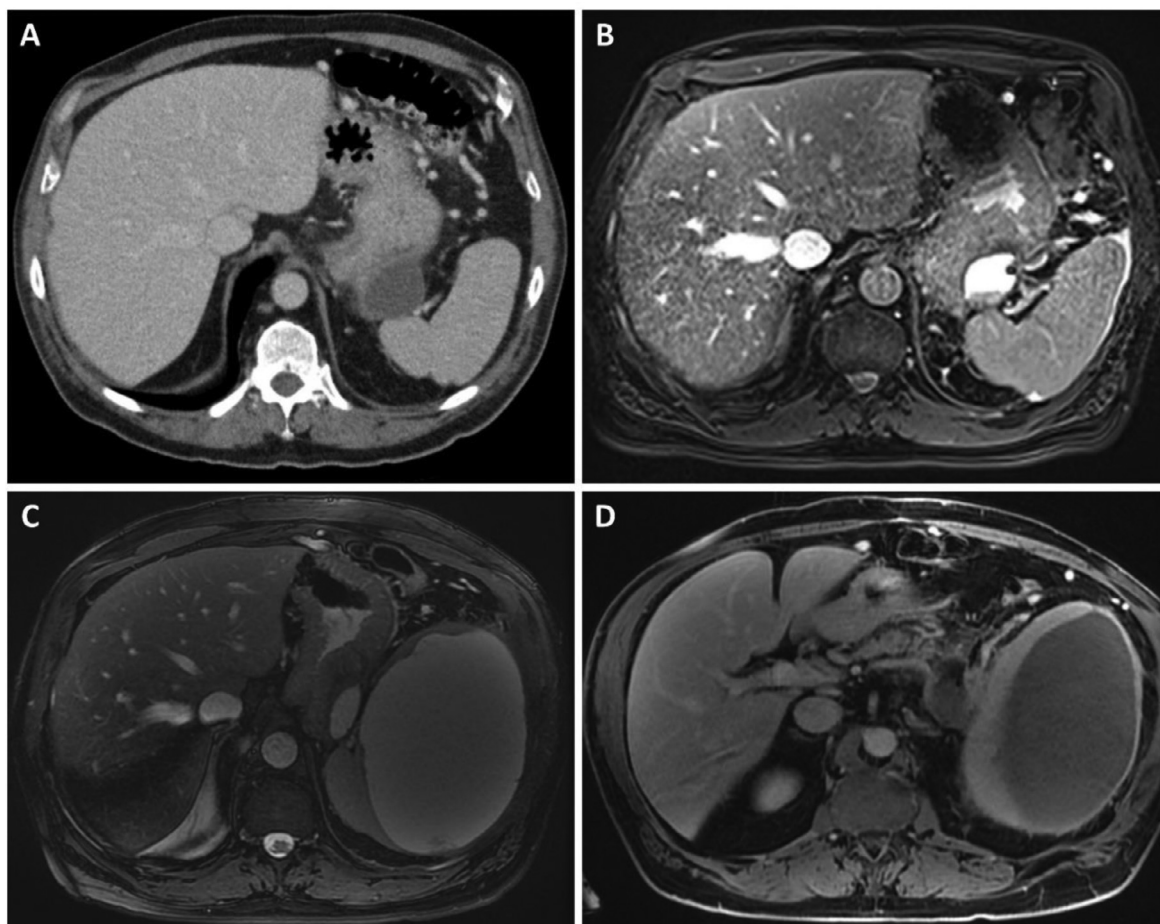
Axial CT scan (A) showing an irregular loculated fluid collection in the tail of the pancreas area measuring $1.6 \times 5.5 \times 4.5$ cm, axial T2 fat sat-weighted MRI image (B) showing persistent complex cystic mass in the pancreatic tail with some heterogeneous signal intensity. Axial 2D FIESTA and T1 fat-suppressed, postcontrast-weighted MRI (C and D) showing mild interval decrease in size of the 2 communicating cystic lesions at the pancreatic tail with interval development of a huge subcapsular fluid collection along the lateral aspect of the spleen. Within these fluid collections there are no enhancing soft tissue components.
